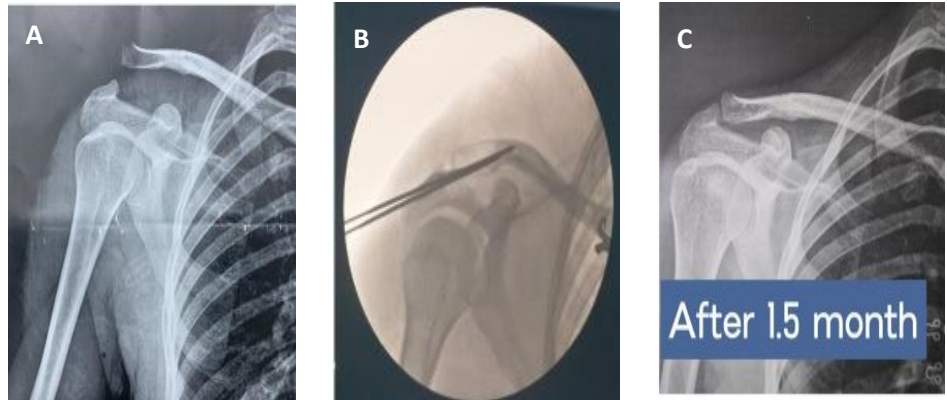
Male patient 35 years old, worker with Rt sided AC joint injury due to sport injury treated by screw A) preoperative x-ray finding, B) intra-operative fluoroscopy show fixation with screw. C) one and half month post-operative follow up x-ray.
